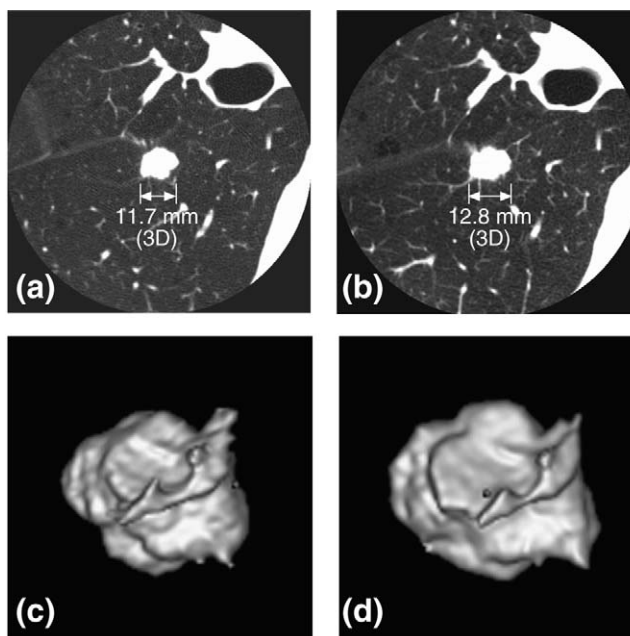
Determining nodule growth rate with volumetric measurements. Multiple images of a nodule, measured 1 mo apart, are shown. The volume at each time instance was measured using GE Medical System's Advanced Lung Analysis program. (a) Using the CT image of the nodule measured at time one, the diameter of the nodule is shown to be 11.7 mm. (b) The same nodule measured one month later is 12.8 mm in diameter. (c) Three-dimensional surface model of the nodule measured at time one. (d) Three-dimensional surface model of the same nodule measured at time two. This nodule exhibited a 24% increase in volume, corresponding to a 103-day doubling time assuming exponential growth. (Courtesy of The Early Lung Cancer Action Program, New York Presbyterian Hospital, Weill Cornell Medical Center, New York, NY.)
